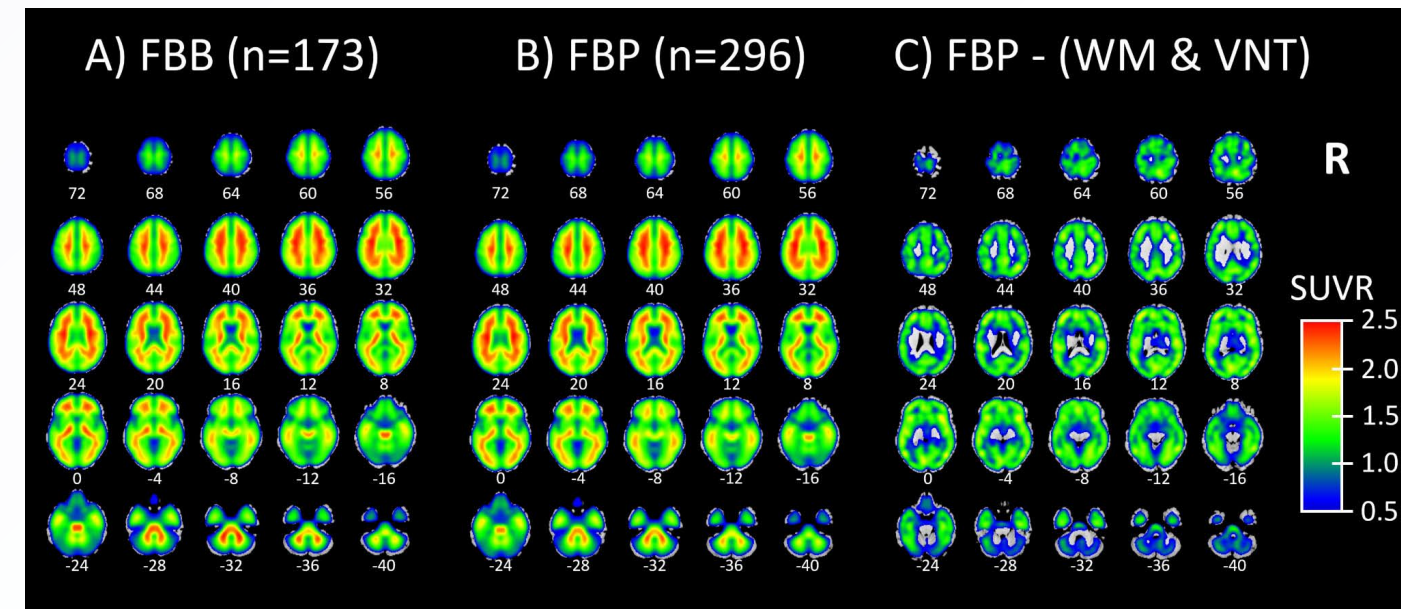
A) Molecular Image Brain Atlas (MIBA) average from 173 florbetaben participants. B) MIBA average of 296 florbetapir participants. C) Florbetapir MIBA average subtracted by white matter (WM) and ventricular (VN) related independent components. In (C) it is seen that the subtraction of WM and ventricles leaves the SUVR signal in gray matter. From [29], Copyright © 2025, The Authors.
